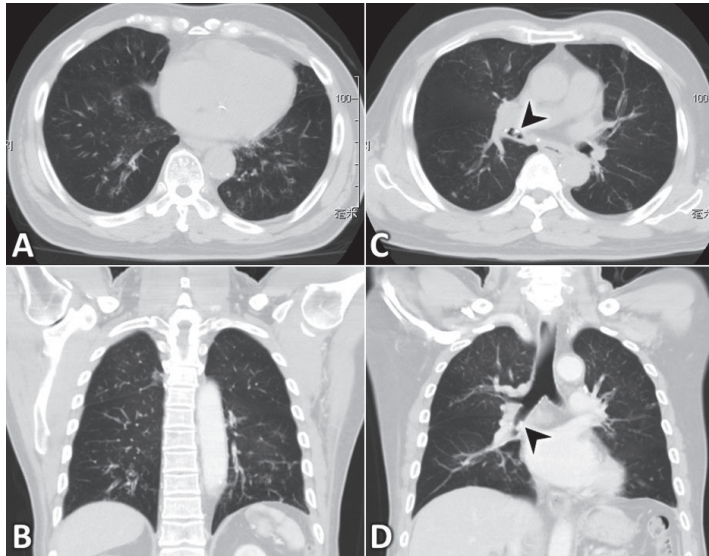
Computed tomography scan of the patient revealed (A)(B) a tree-in-bud pattern (marked with white arrowheads) with centrilobular nodules with a linear branching pattern at the bilateral lower lobes, and (C)(D) an endobronchial hyperdense lesion (marked with black arrowheads) in the lower part of the right main bronchus.
